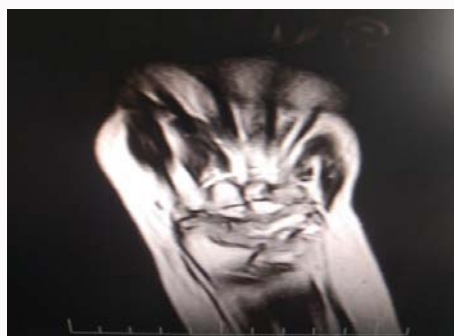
Coronal T2- weighted MRI of the left wrist.
